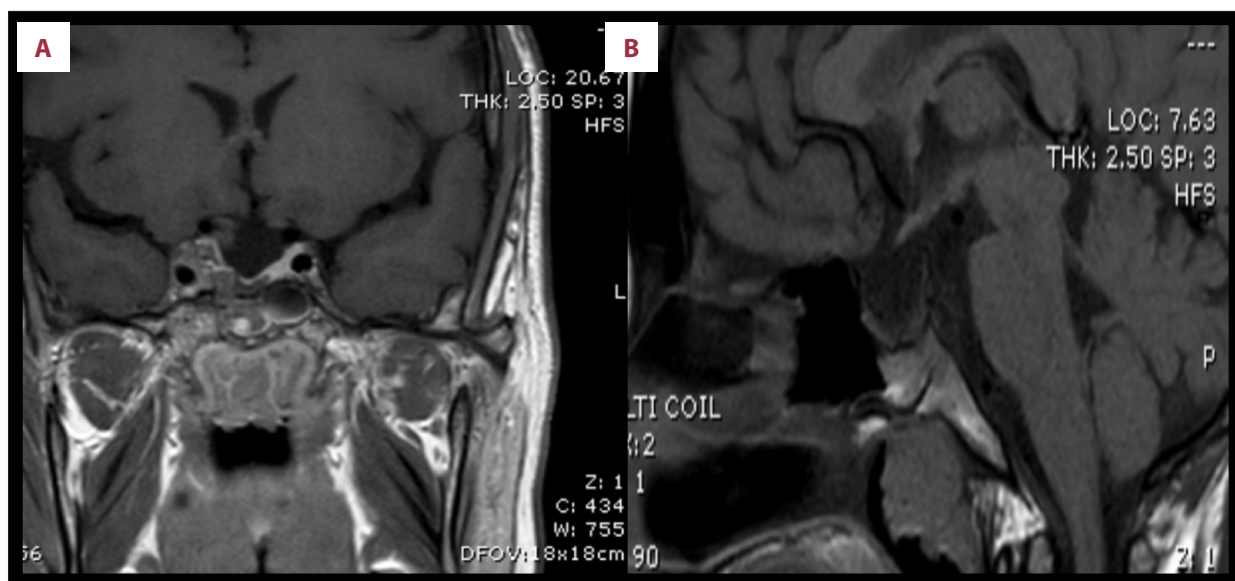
(A) Post-operative contrast-enhanced coronal T1-weighted magnetic resonance imaging (MRI) of the sellar region demonstrating complete resection of the pituitary macroadenoma following repeat transsphenoidal surgery. The sellar cavity appears decompressed with no evidence of residual enhancing tumor and with preserved suprasellar structures and cavernous sinuses. (B) Post-operative sagittal T1-weighted pituitary MRI obtained after repeat transsphenoidal resection demonstrating complete removal of the pituitary tumor with restoration of normal sellar anatomy.
